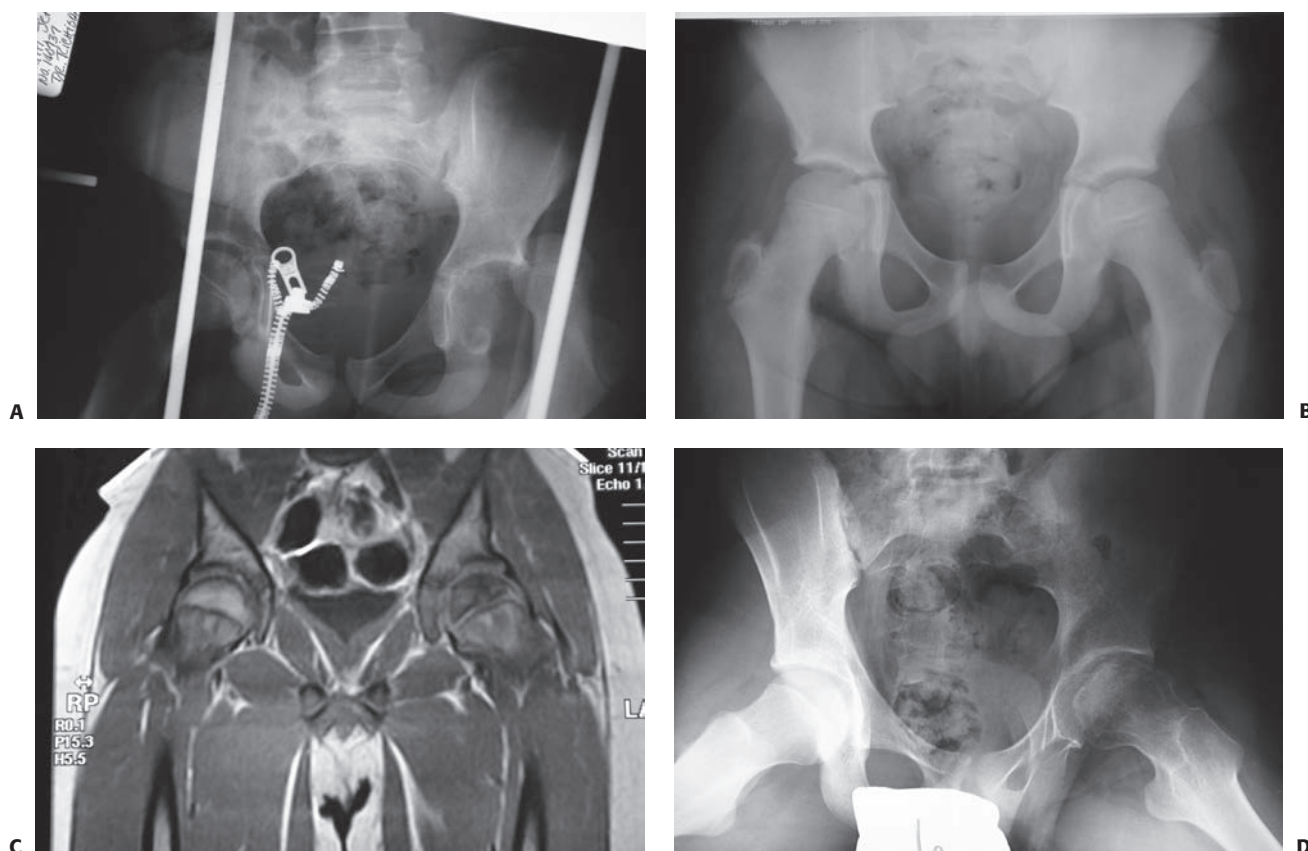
A: An 11-year-old boy dislocated his left hip while wrestling. B: The hip was easily reduced. C: After 5 months, hip pain led to an MRI, which shows ON of the capital femoral epiphysis. D: At 10 months after injury, there are typical changes of ON despite nonweight bearing.
